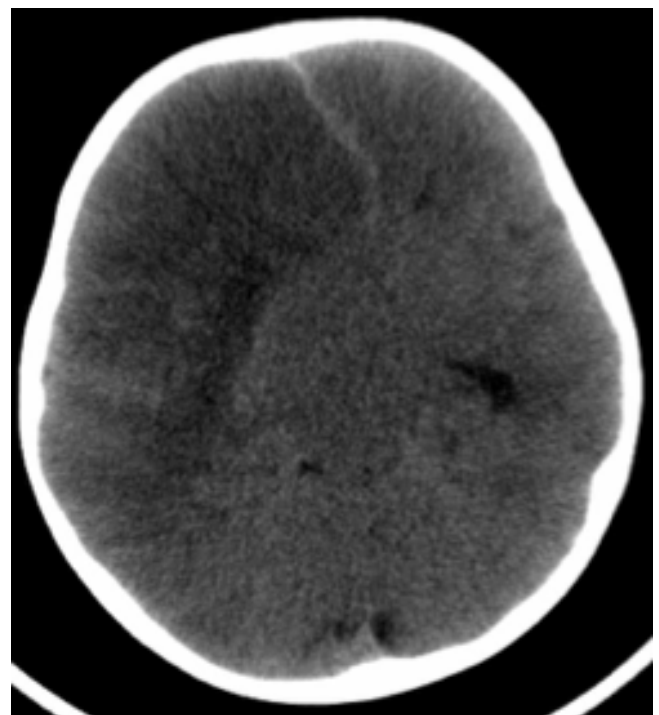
Subfalcine herniation in CT image of second patient
